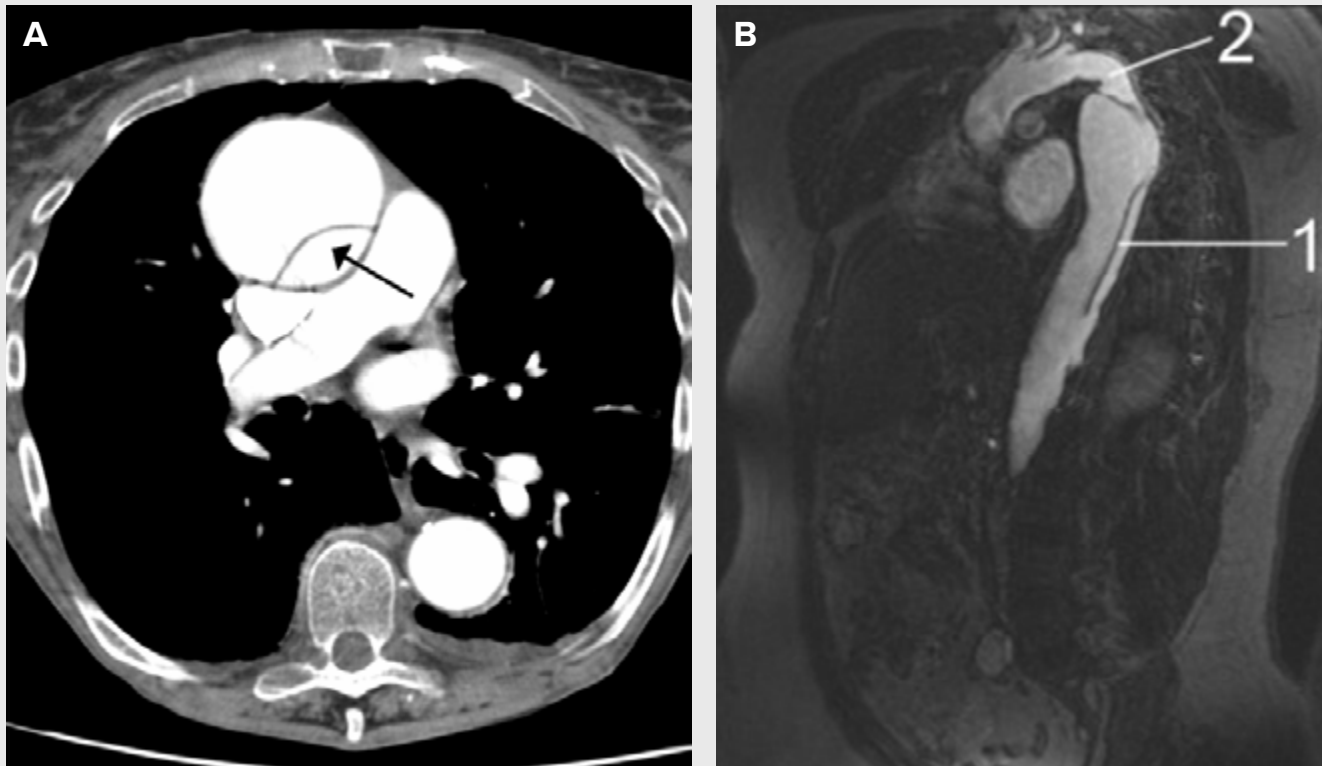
(A) CT scan of an aortic dissection. (B) MRT scan of aortic dissection.
